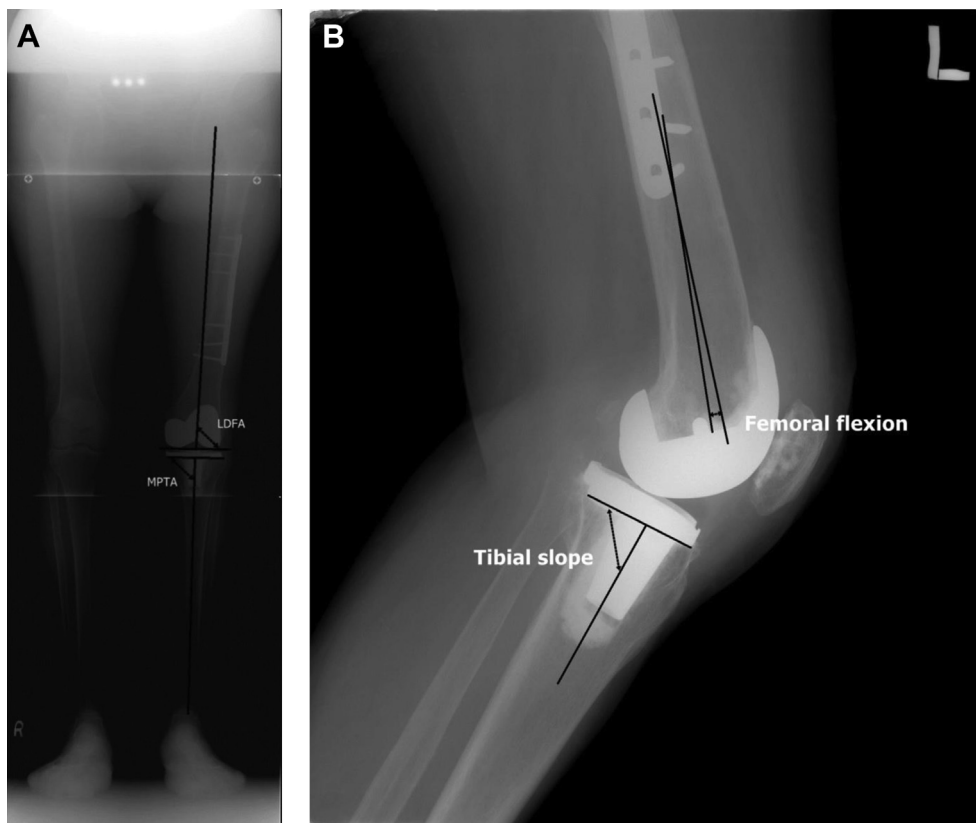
Postoperative radiographs of a 62-year-old woman with retained femoral implants (Patient 7 in Table 1). (A) Full-length standing radiograph demonstrating the lateral distal femur angle (LDFA) and medial proximal tibial angle (MPTA). (B) Standard lateral radiograph demonstrating the femoral flexion and the tibial slope.
